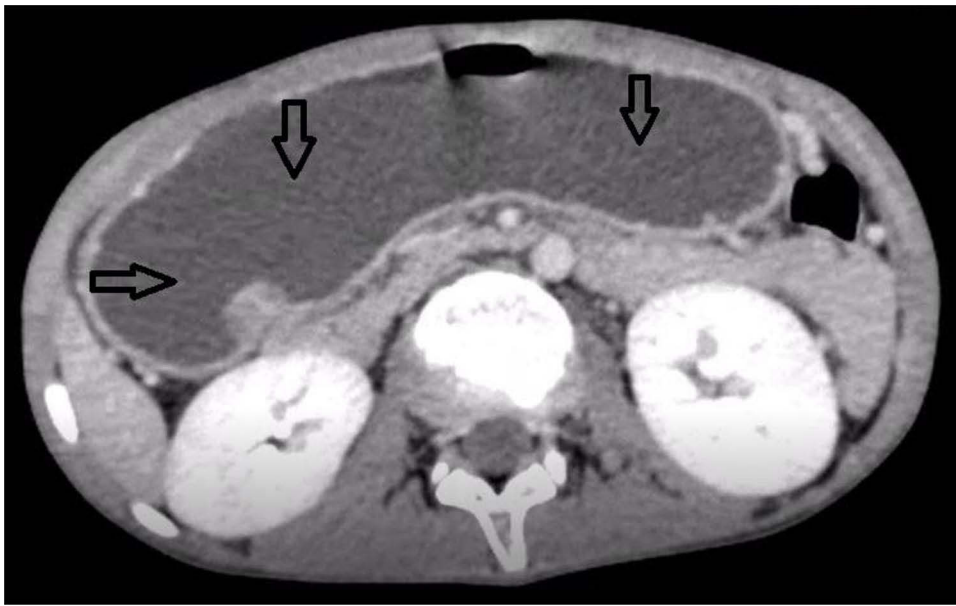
Abdominal CT shows marked distension of the stomach (thick arrows) with abrupt tapering of the first part of the duodenum and collapse of the rest of the duodenum.
